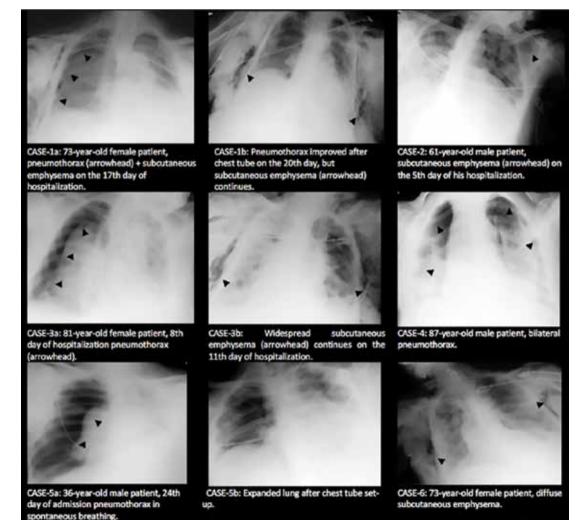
Examples of bedside radiography
